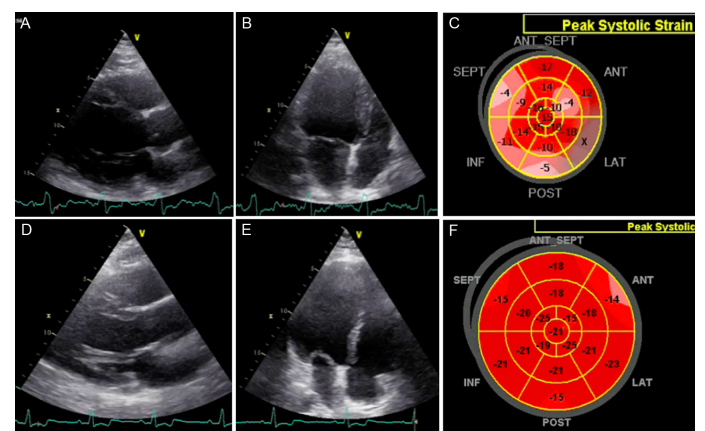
Echocardiography (A-B) and strain echocardiography Bull's eye (C) images of case 1 and echocardiography (D-E) and strain echocardiography Bull's eye (F) images of case 2. Left ventricular hypertrophy with global hypokinesia and decreased GLS could be seen in A-C. Left ventricular hypertrophy with normal ejection fraction and within normal limits GLS could be seen in D-F (A and D: parasternal long axis view, B and E: apical 4-chamber view) (Video 1-2-3-4). GLS, global longitudinal strain.
